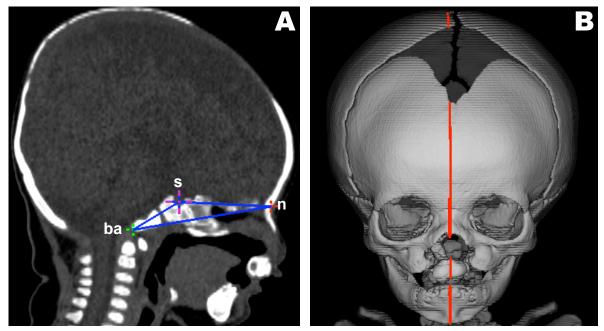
Computed tomography images of the reference plane constructed from 3 osseous landmarks: nasion (n), sella (s), and basion (ba). (A) Sagittal view of "wire frame" constructed midline reference plane. (B) Frontal view of reference plane bisecting a BCLP patient.
